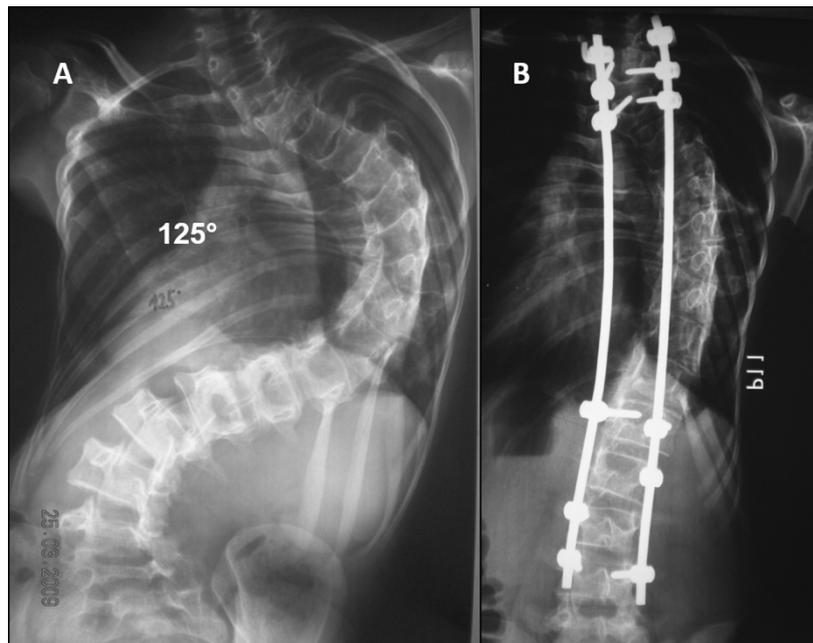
An X-ray of the patient treated with TGR: A – pre-operatively, B – after first surgery
